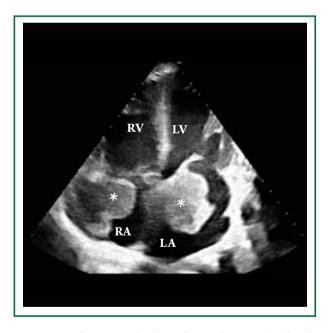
Two-dimensional echocardiographic apical 4-chamber view showing the tumor (*) invading both atria.
